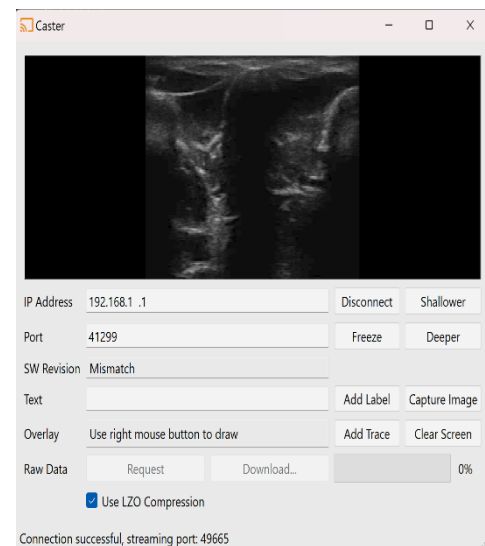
The Caster API user interface utilizes the IP address from IOS/Android device in addition to port number information given on the mobile application to receive ultrasound images as seen in the top of the screen.
